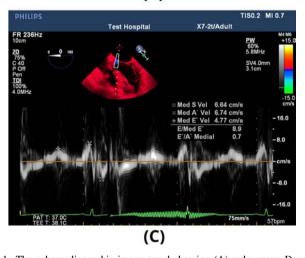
The echocardiographic image panel showing (A) pulse wave Doppler across the mitral valve showing the peak transmitral early diastolic velocity (E=42.5~cm/s) and the duration from R wave to E wave (567 ms); (B) tissue Doppler estimation of the E/e' at the lateral annulus (6.4); (C) tissue Doppler estimation of the E/e' at the septal (medial) annulus (8.9). Thus, the resultant E/e' (7.51) is computed as the average of the E/e' across the 2 annuli.
